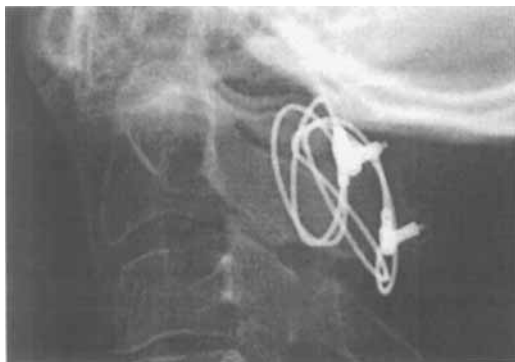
Radiographic bone formation at the implantation site at 6 months. This patient was on 7.5 mg prednisolone daily. Bone formation was found after partial redislocation.
